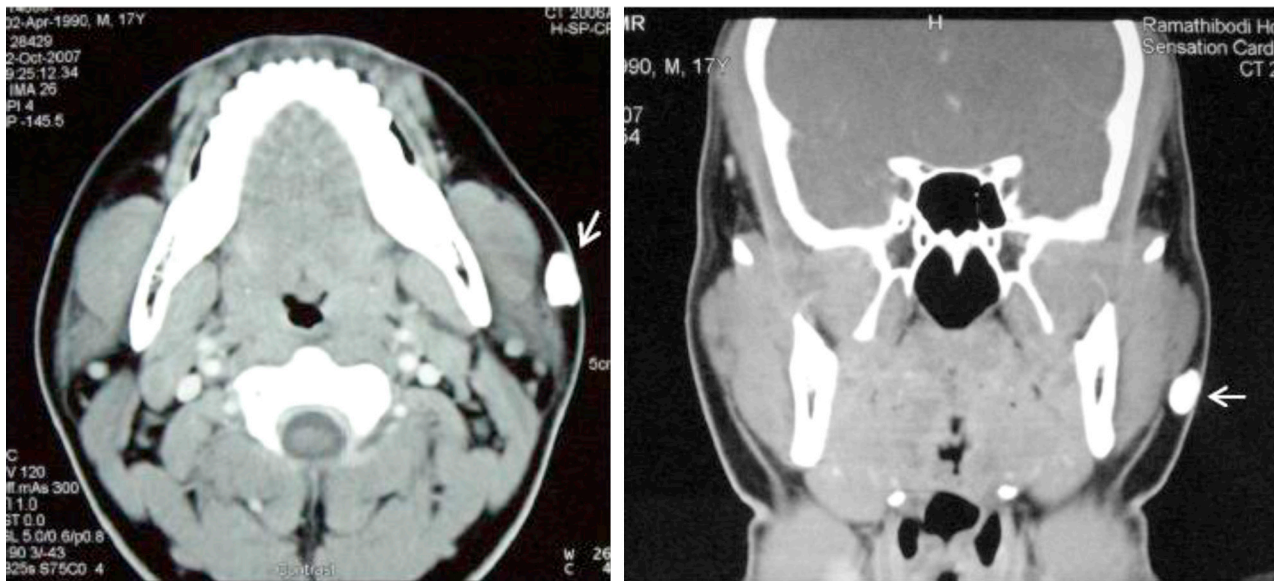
Radiopaque of calcification-like mass in subcutaneous tissue layer, superficial to the muscle and the preauricular gland shown in computed tomography (arrow).
